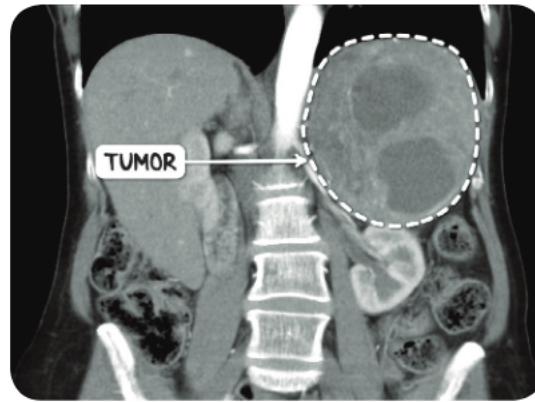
An abdominal CT scan in the coronal plane demonstrating a large adrenal pheochromocytoma on the left hand side.
